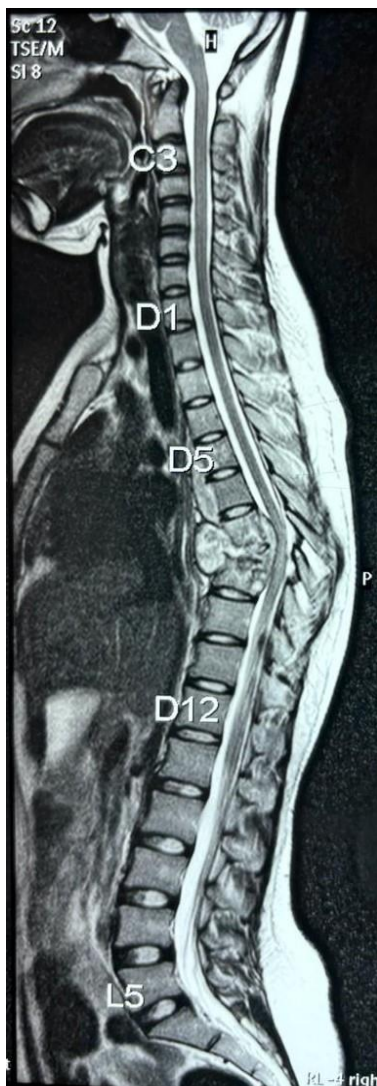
Sagittal cuts of MRI suggestive of T7 to T9 vertebral collapse and complete destruction associated with localized abscess from T5 to T10 levels associated with kyphotic deformity.
